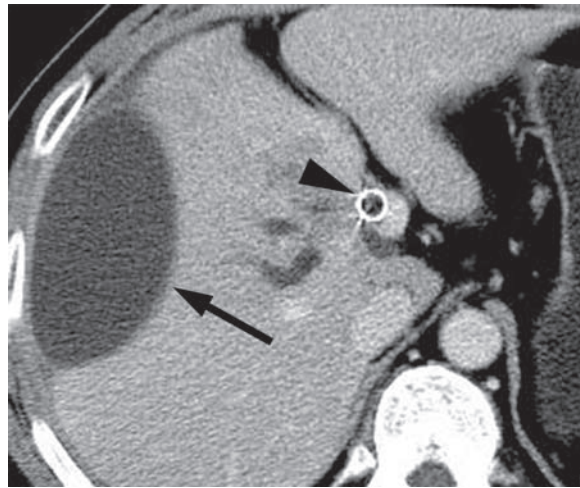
Subcapsular biloma in a 54-year-old man with bile duct cancer. Contrast material–enhanced CT scan shows a lentiform fluid collection and indentation of the underlying liver margin (arrow). Note the metallic stent at the common hepatic duct (arrowhead).
